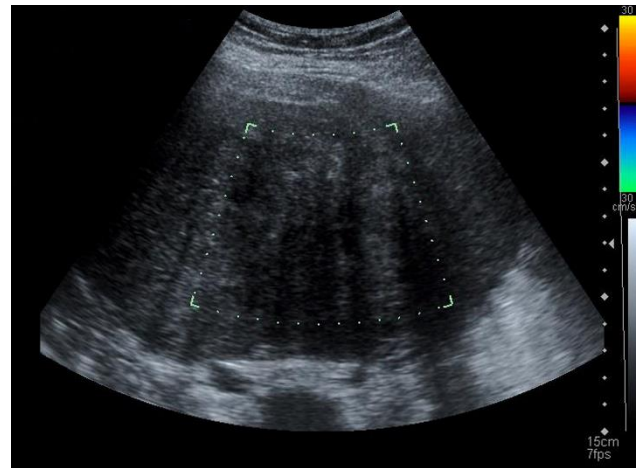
Color doppler examination shows no vascular flow in the solid mass
